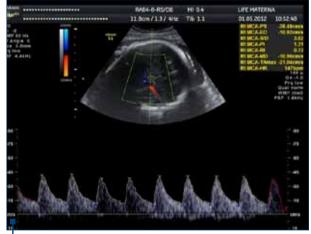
Doppler examinations at 40 weeks with normal spectrum and parameters
